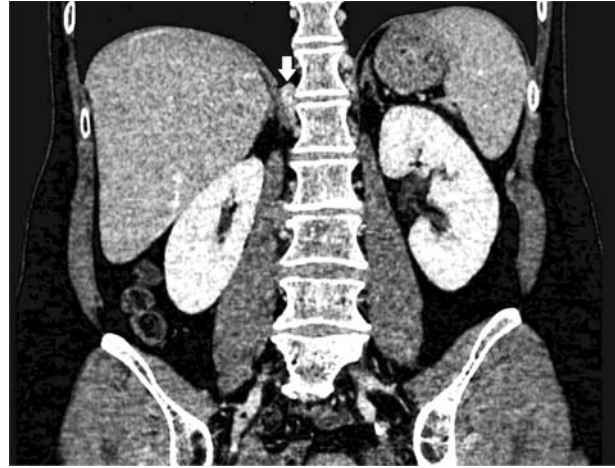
Contrast enhanced abdominal CT – multi-planar coronal reconstruction: small mass in right retrocrural space, same CT characteristics as liver tissue but without tissue or vascular connection to the liver – CT feature of ectopic liver lobe
